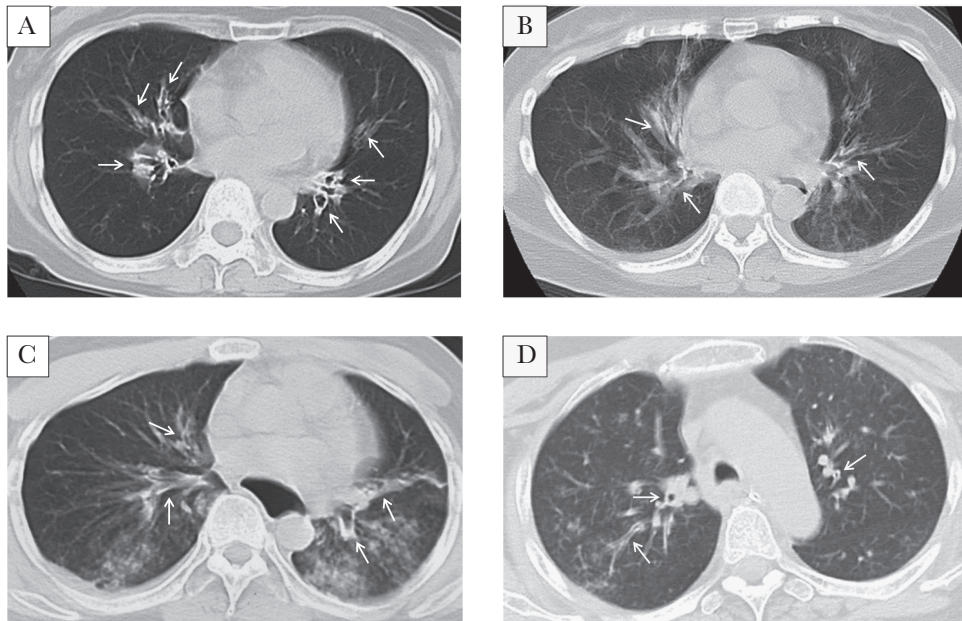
Representative chest computed tomography (CT) images in human metapneumovirus pneumonia. Bronchial wall thickenings in the proximal bronchus (A, B, C, and D) and multiple lobular opacities (C and D) were observed. Chest CTs obtained from a (A) 61-year-old female, (B) 59-year-old female, (C) 36-year-old male, and (D) 55 year-old female are shown. White arrows indicate bronchial wall thickenings.
